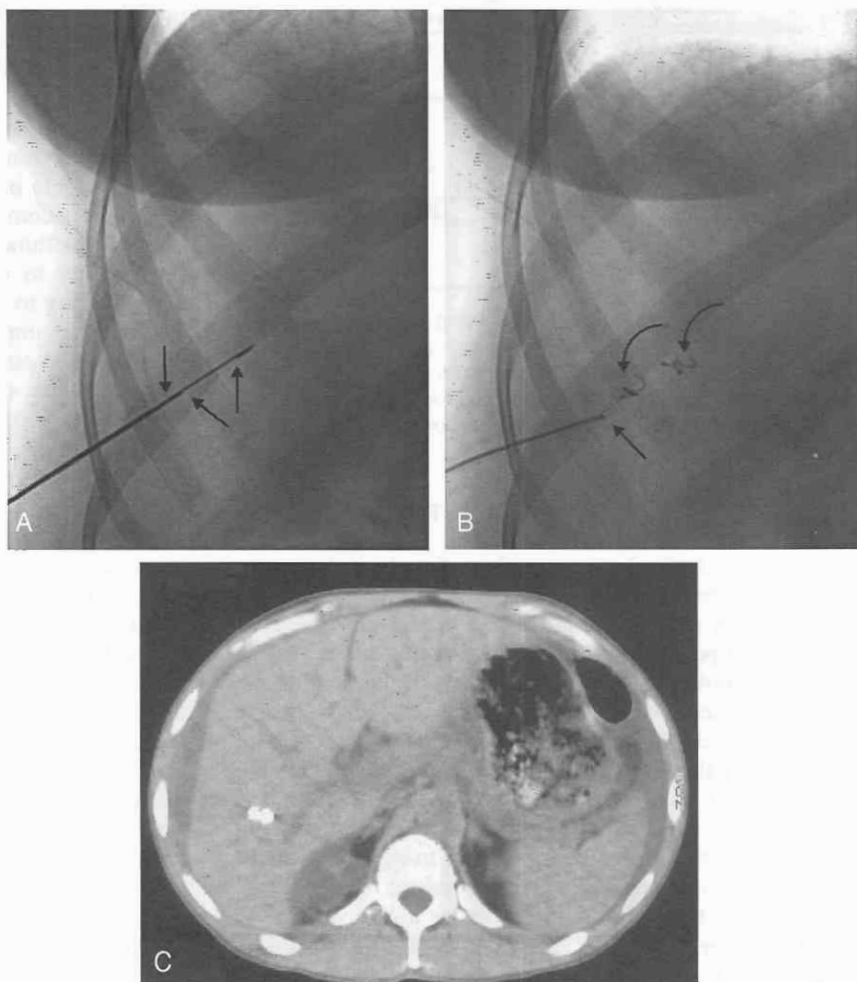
A, Radiograph shows fluoroscopically guided placement of coil. The guidance cannula (*long arrow*) is noted proximally, and the “gap” (*small arrows*) of the cutting needle is noted distal to the cannula. B, Follow-up image shows the cannula containing an angiographic wire, after pushing the two steel coils into the liver (*curved arrows*). C, Follow-up CT scan shows the coil in the liver.
